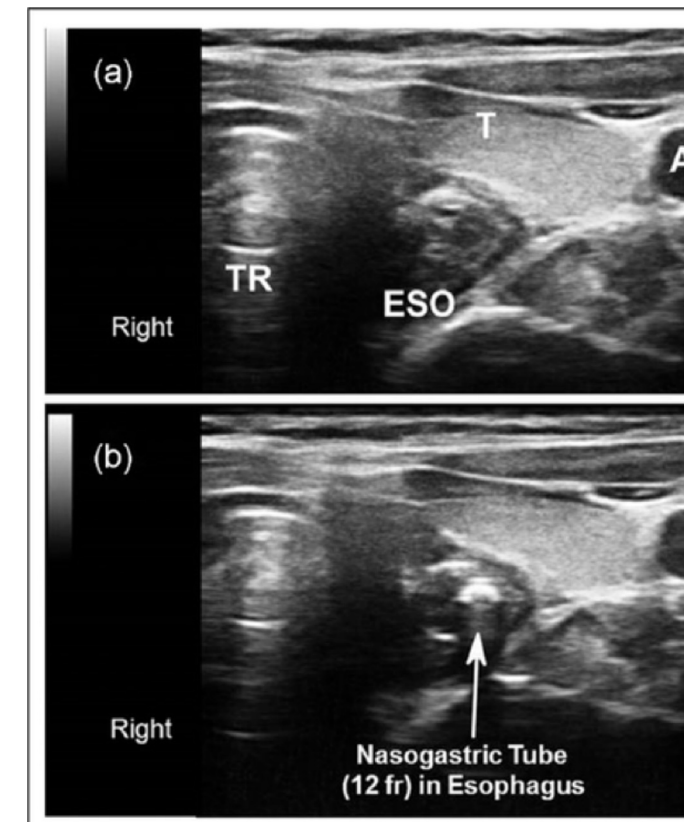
Nasogastric tube placement in esophagus on ultrasonography (Kim HM, *Scandinavian Journal of Trauma, Resuscitation, and Emergency Medicine*. 2012.)
